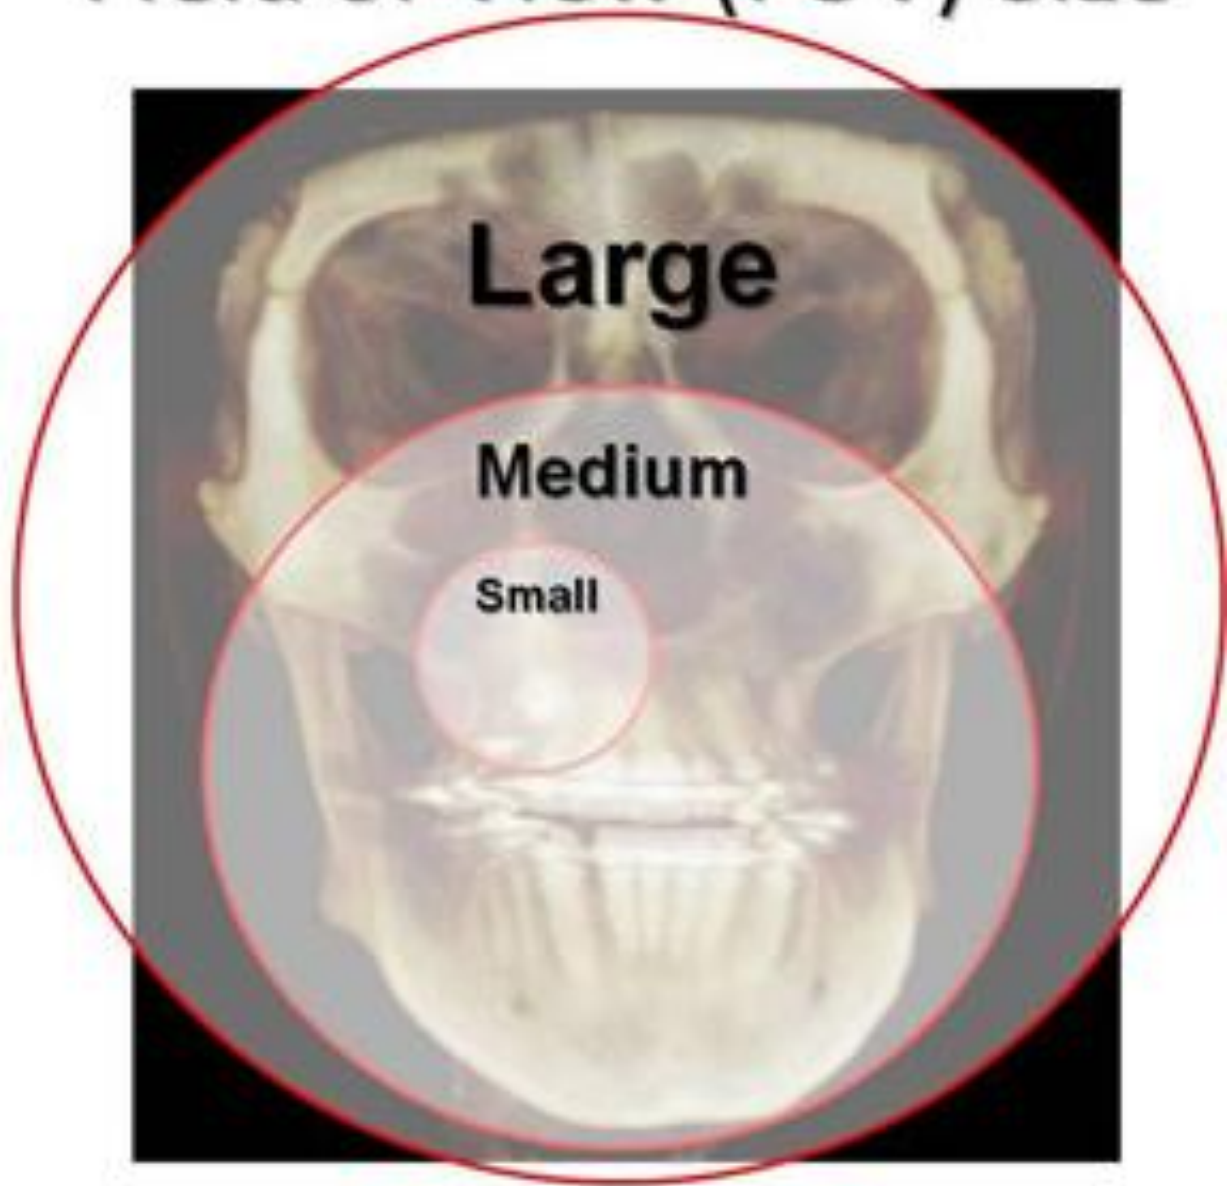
CBCT scanners with different Field of views -small, medium & large.
